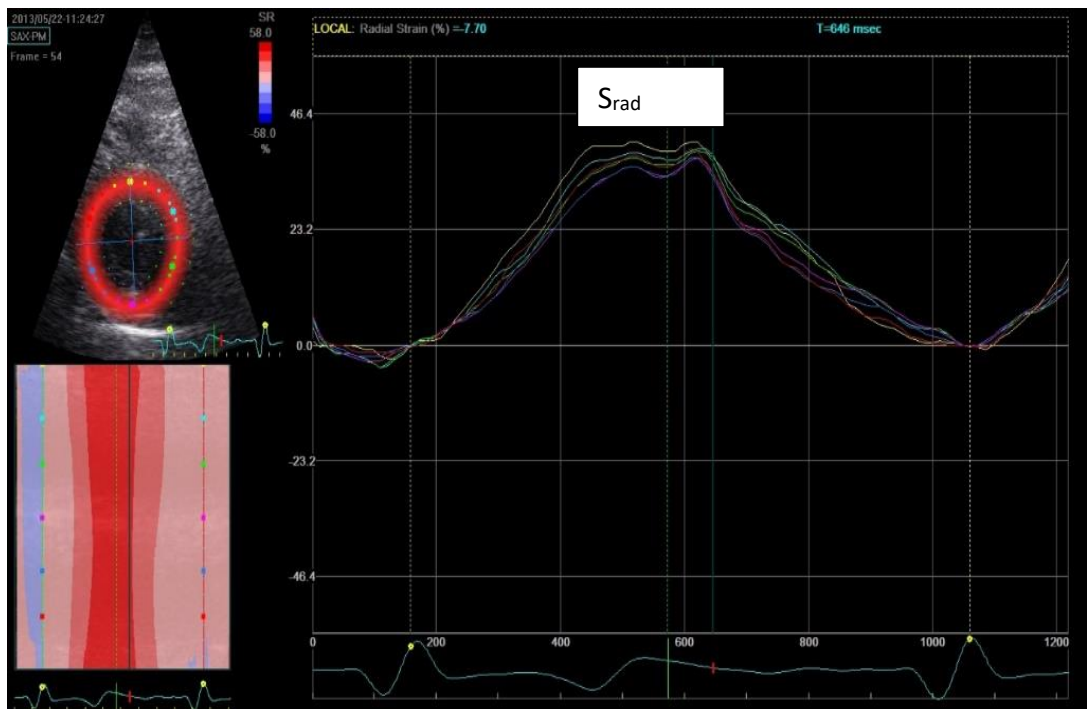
Radial (top) and circumferential (bottom) 2DSTE strain graphs at mid LV (parasternal short-axis view).
